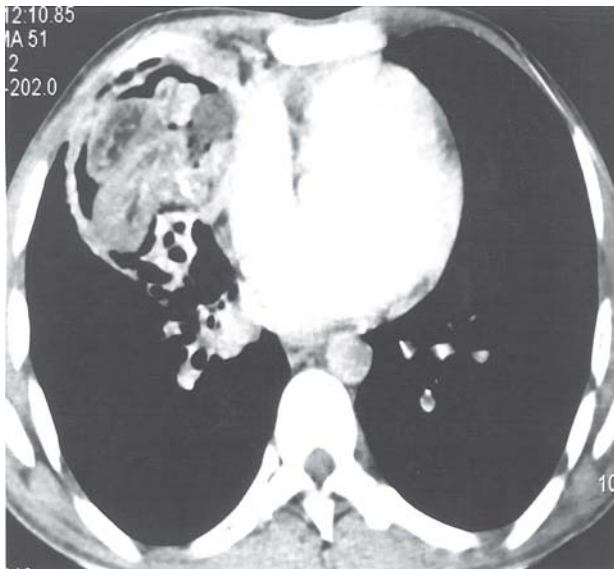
Computed tomography of thorax showing a heterogeneous mass in the right lung with areas of fat attenuation, calcification and solid components with air-lucent rim around the mass.
